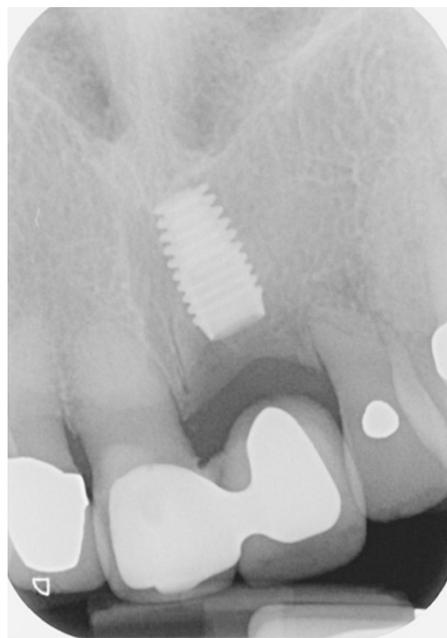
After open flap debridement, decontamination of the external and internal surfaces of the implant soft tissue closure was achieved. Note the presence of radiographic bony infill. On review she preferred to maintain the resin bonded bridge rather than revisit an implant restoration on the 21
